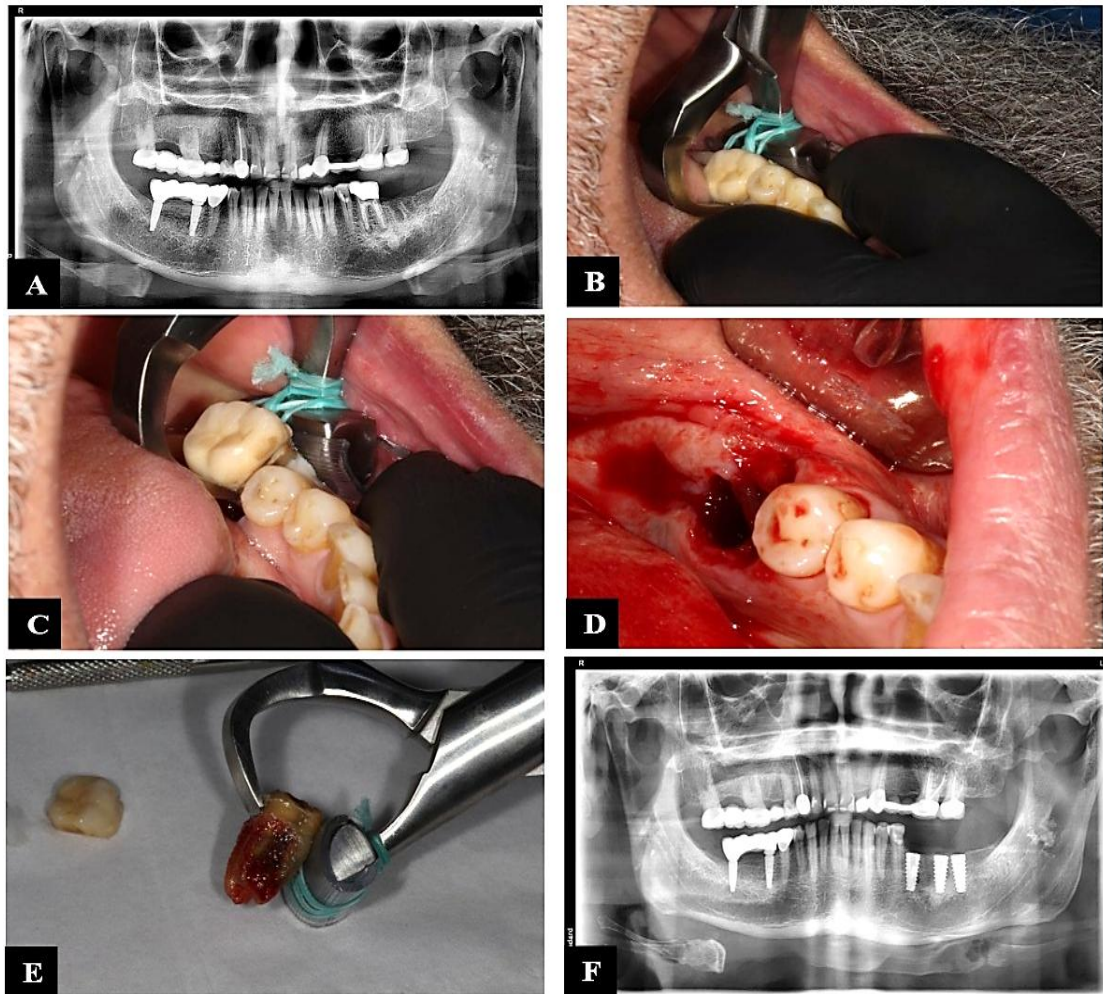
A) Preoperative radiograph (O.P.G.) of mandibular left 1st molar. B) The tooth grasped with physics forceps, with the beak inserted into the lingual gingival sulcus and bumper placed buccally near the mucogingival junction. C) Tooth luxated from the socket. D) Socket immediately after extraction. E) The tooth after extraction. F) Postoperative radiograph (O.P.G.) after implant placement.
